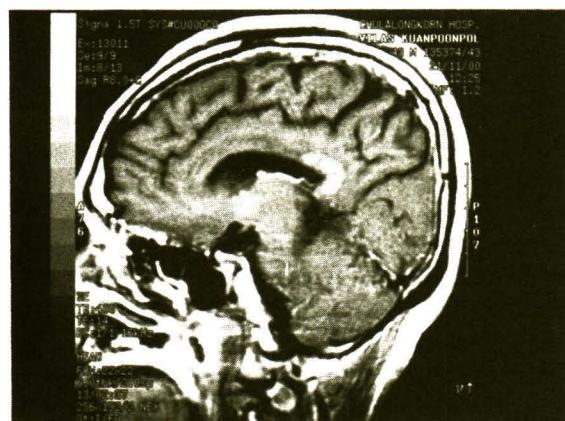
Sagittal T1WI MRI with gadolinium enhancement demonstrates an enhanced lesion at the splenium of the corpus callosum.
